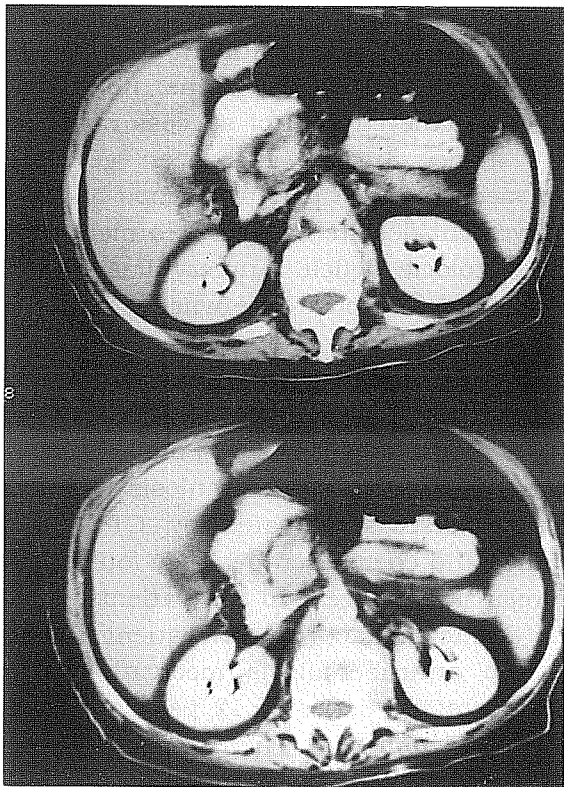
(a) CT scan shows a pyogenic abscess in the right psoas, (b) The catheter in the abscess, (c) Three months later, CT scanning reveals an improvement completely.
